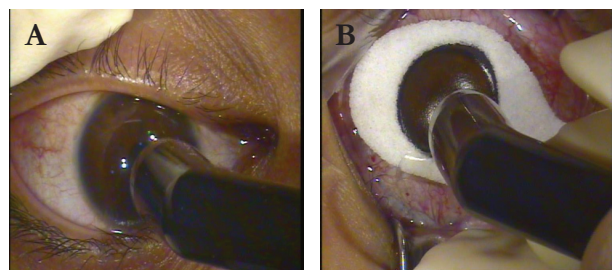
Ultrasonic pachymetry before (A) and after (B) flap cut.
